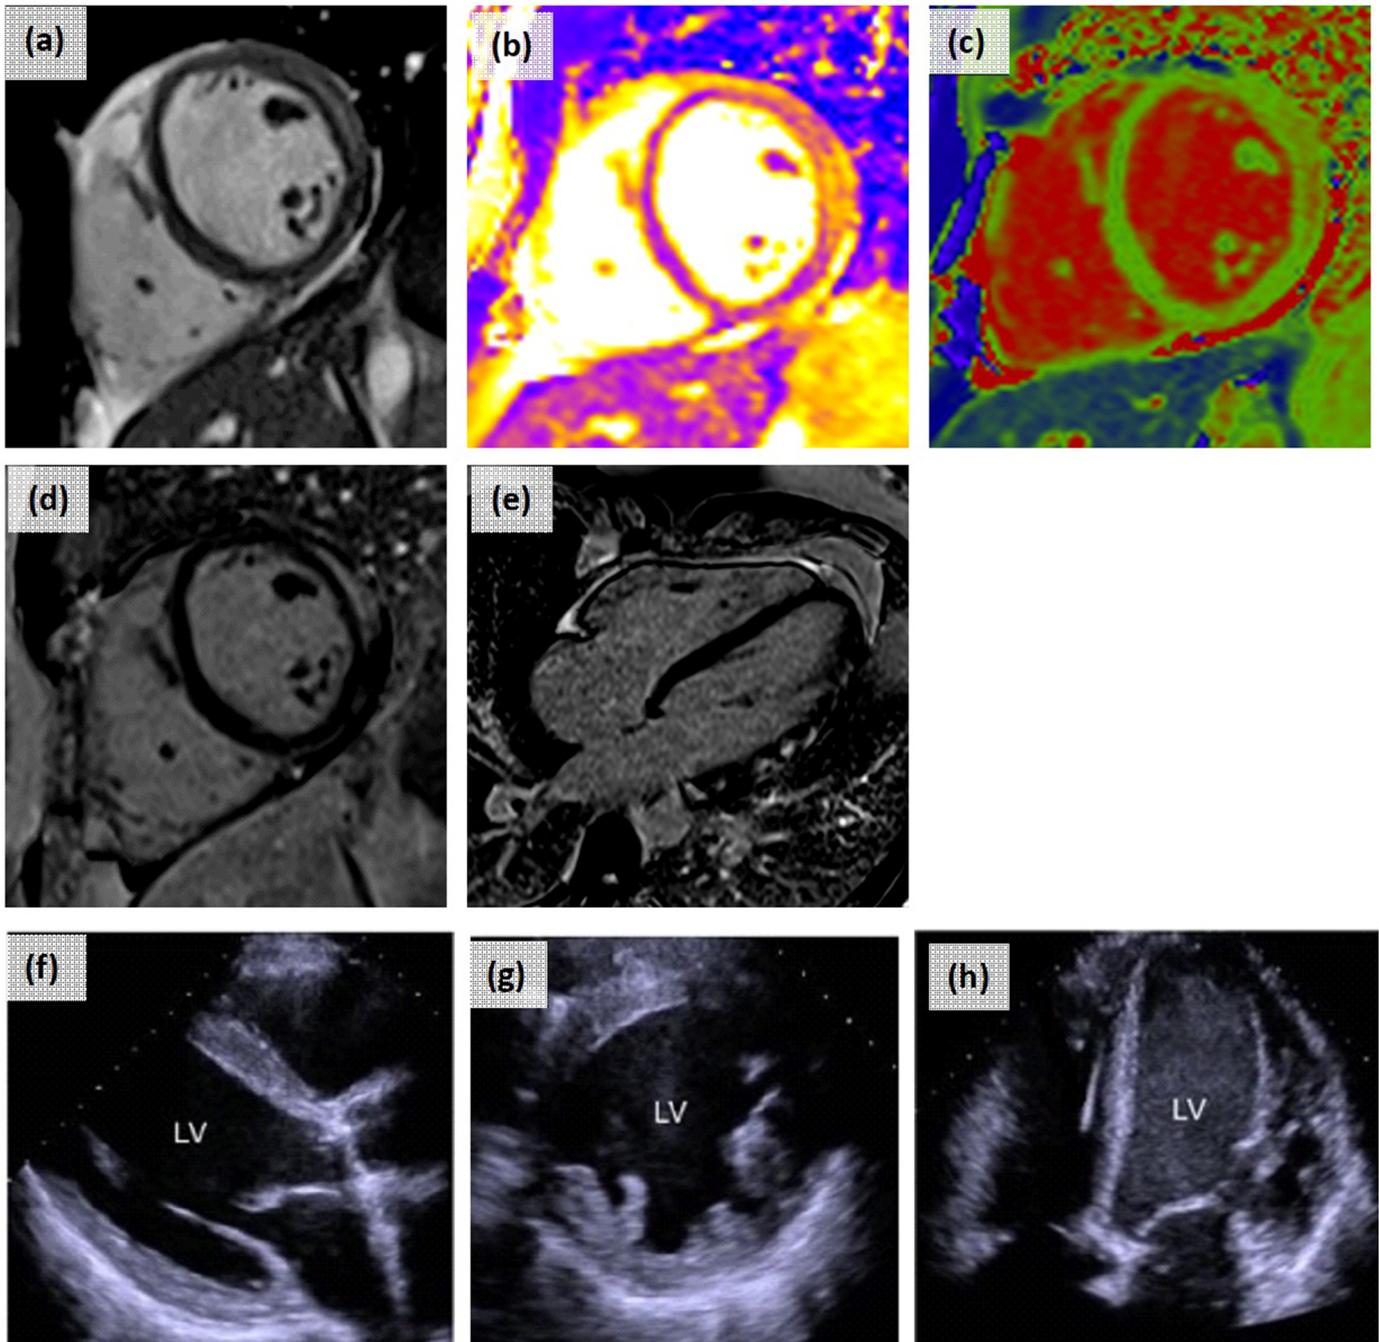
Cardiac imaging in myocarditis and cardiomyopathy. Cardiac Magnetic Resonance Imaging (CMRI) demonstrating myocarditis. Cine imaging following gadolinium contrast (a) shows high signal in the lateral wall corresponding to high T2 values (b) T1 values (c) and patchy subepicardial late gadolinium enhancement seen in short-axis (d) and long-axis (e) views. Transthoracic Echocardiogram (TTE) demonstrating a dilated left ventricle in the parasternal long axis (f), parasternal short axis (g) and apical 4 chamber windows, which demonstrates evidence of spontaneous echo contrast in the left ventricle, a characteristic feature of left ventricular impairment (h).
